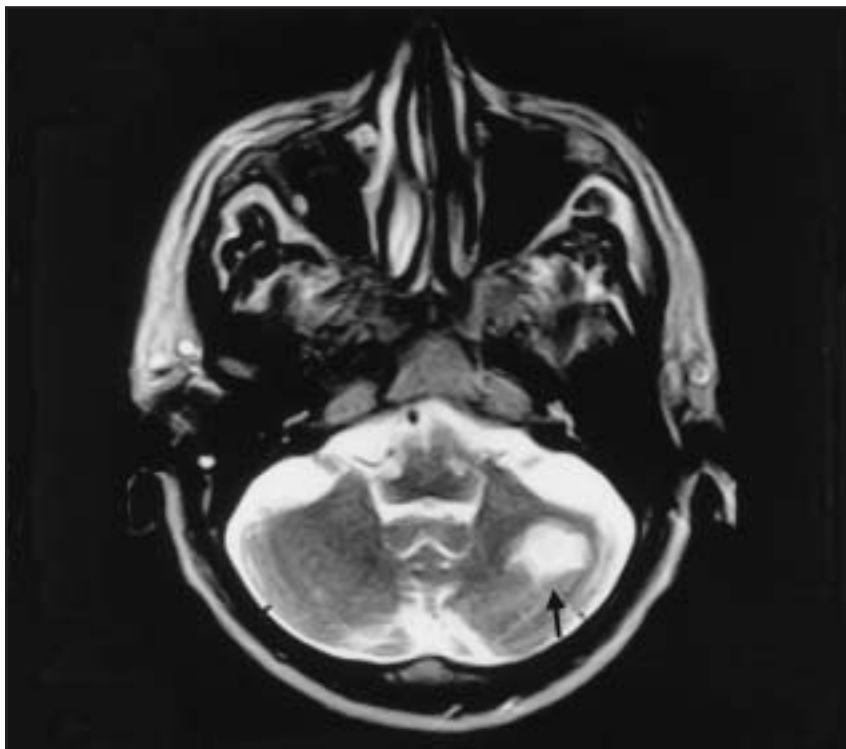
MRI shows a left cerebellar focus of *Fusarium solani* in a patient with acute myelogenous leukemia (arrow).
